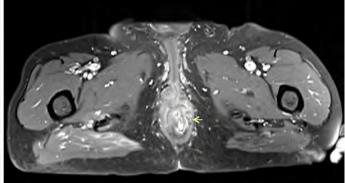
Pelvic MRI (axial view, T1) revealing intersphincteric fistulas with one extending to the prostatic apex/base of the penis (orange arrow) and multifocal disruption of the sphincter planes (green arrow). MRI, magnetic resonance imaging.
